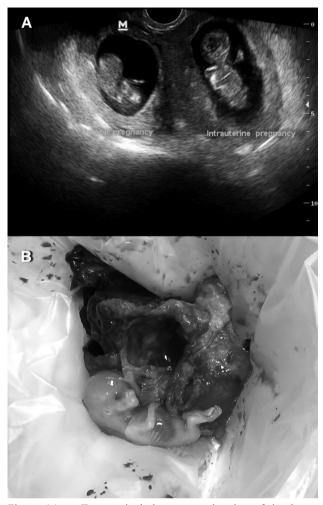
Transvaginal ultrasonography view of simultaneous intra and extra uterine vital pregnancy at week 12. Figure 1B. — Ectopic pregnancy immediately after salpingectomy. The fetus of 12 weeks' gestational age and the stretched right tube can be seen in the figure.
